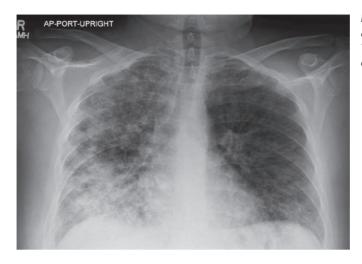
Chest X-ray showing diffuse bilateral infiltrate. The opacities are both alveolar and interstitial.
